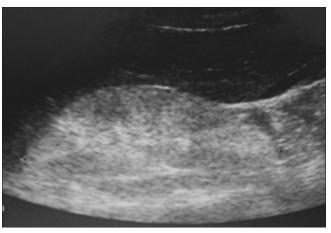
Longitudinal sonogram of the right kidney showing grade III renal echogenicity in a patient with HIVA
